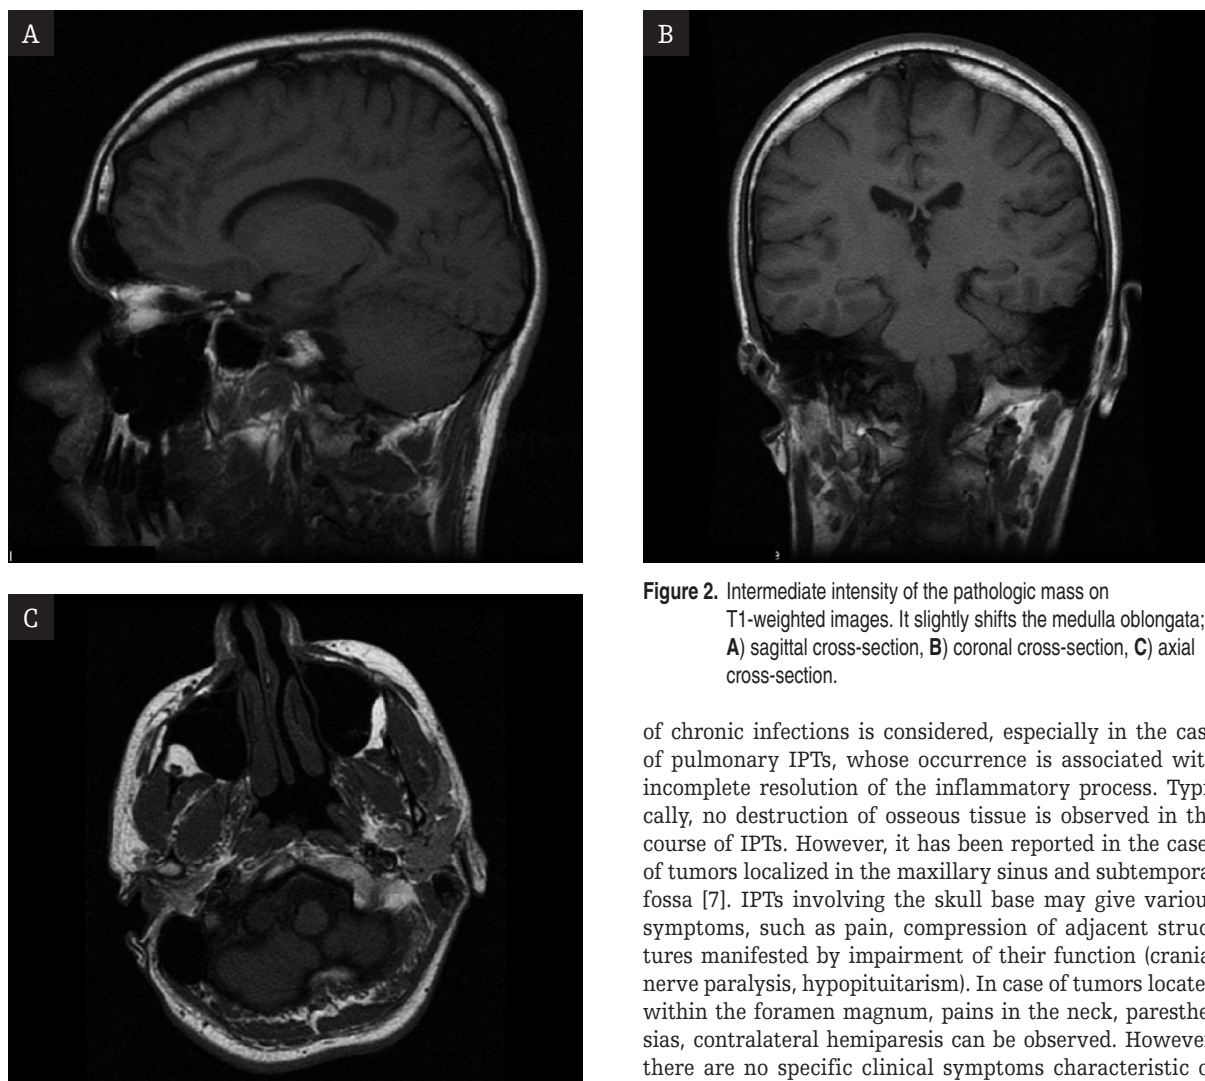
Intermediate intensity of the pathologic mass on T1-weighted images. It slightly shifts the medulla oblongata; A) sagittal cross-section, B) coronal cross-section, C) axial cross-section.
